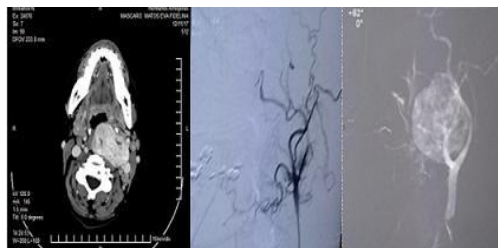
CT angiography and embolization
